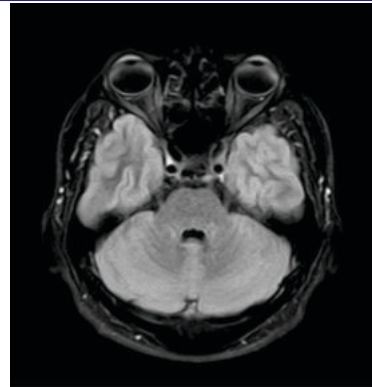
Follow up MRI 6 weeks later – axial T2 FLAIR image shows resolution of altered signal intensities in the dentate nuclei.
